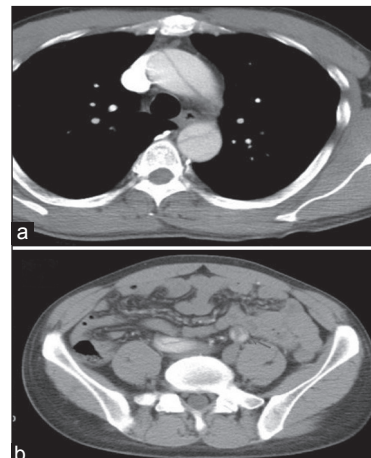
(a) Enhanced contrast-enhanced computed tomography (CECT) scans shows the minimal flap from ascending aorta through descending aorta. (b) Enhanced CECT scans showed true lumen compression by enlarged false lumen. Intimal flap was noted in bi-iliac artery
